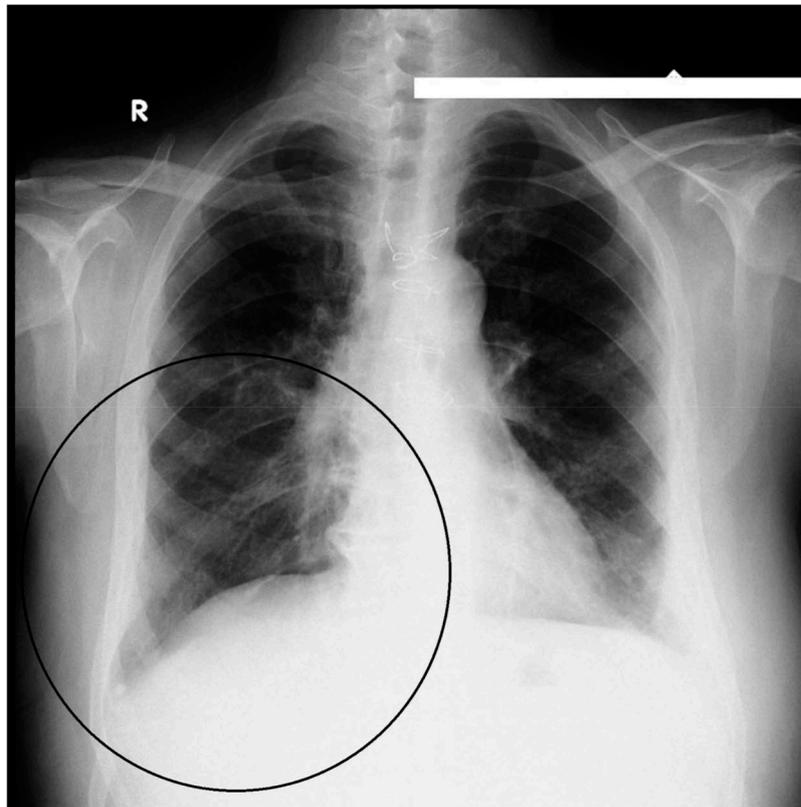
X-Ray Chest (erect) showing no air under the diaphragm.
